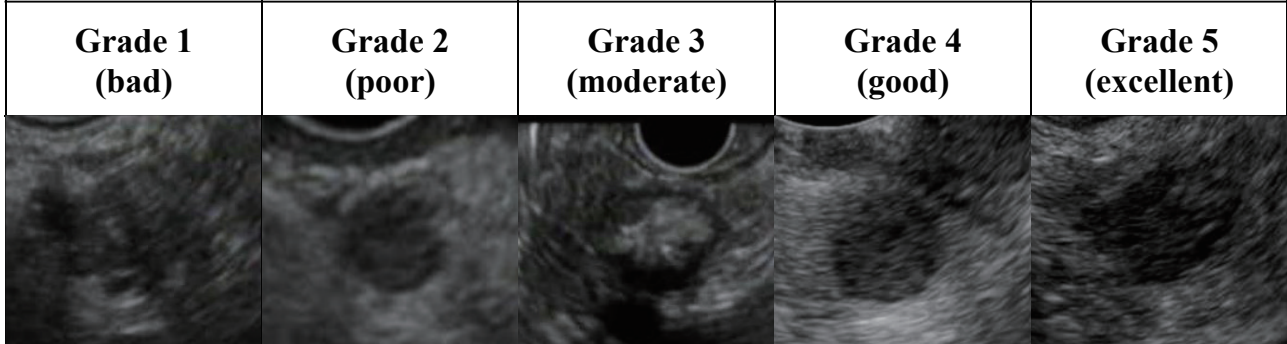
Representative EUS imaging ~Border~. Representative images from each EUS system depicting the border of lesions. As the grade increases, the lesion border becomes clearer. EUS, endoscopic ultrasonography.
